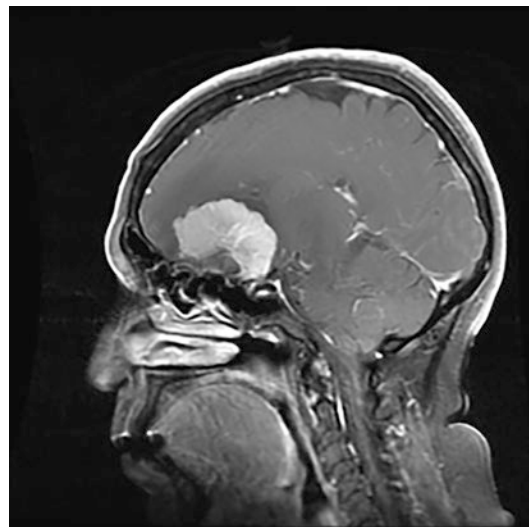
MRI scan of a spheno-orbital meningioma that may be approached with an orbito-zygomatic approach
